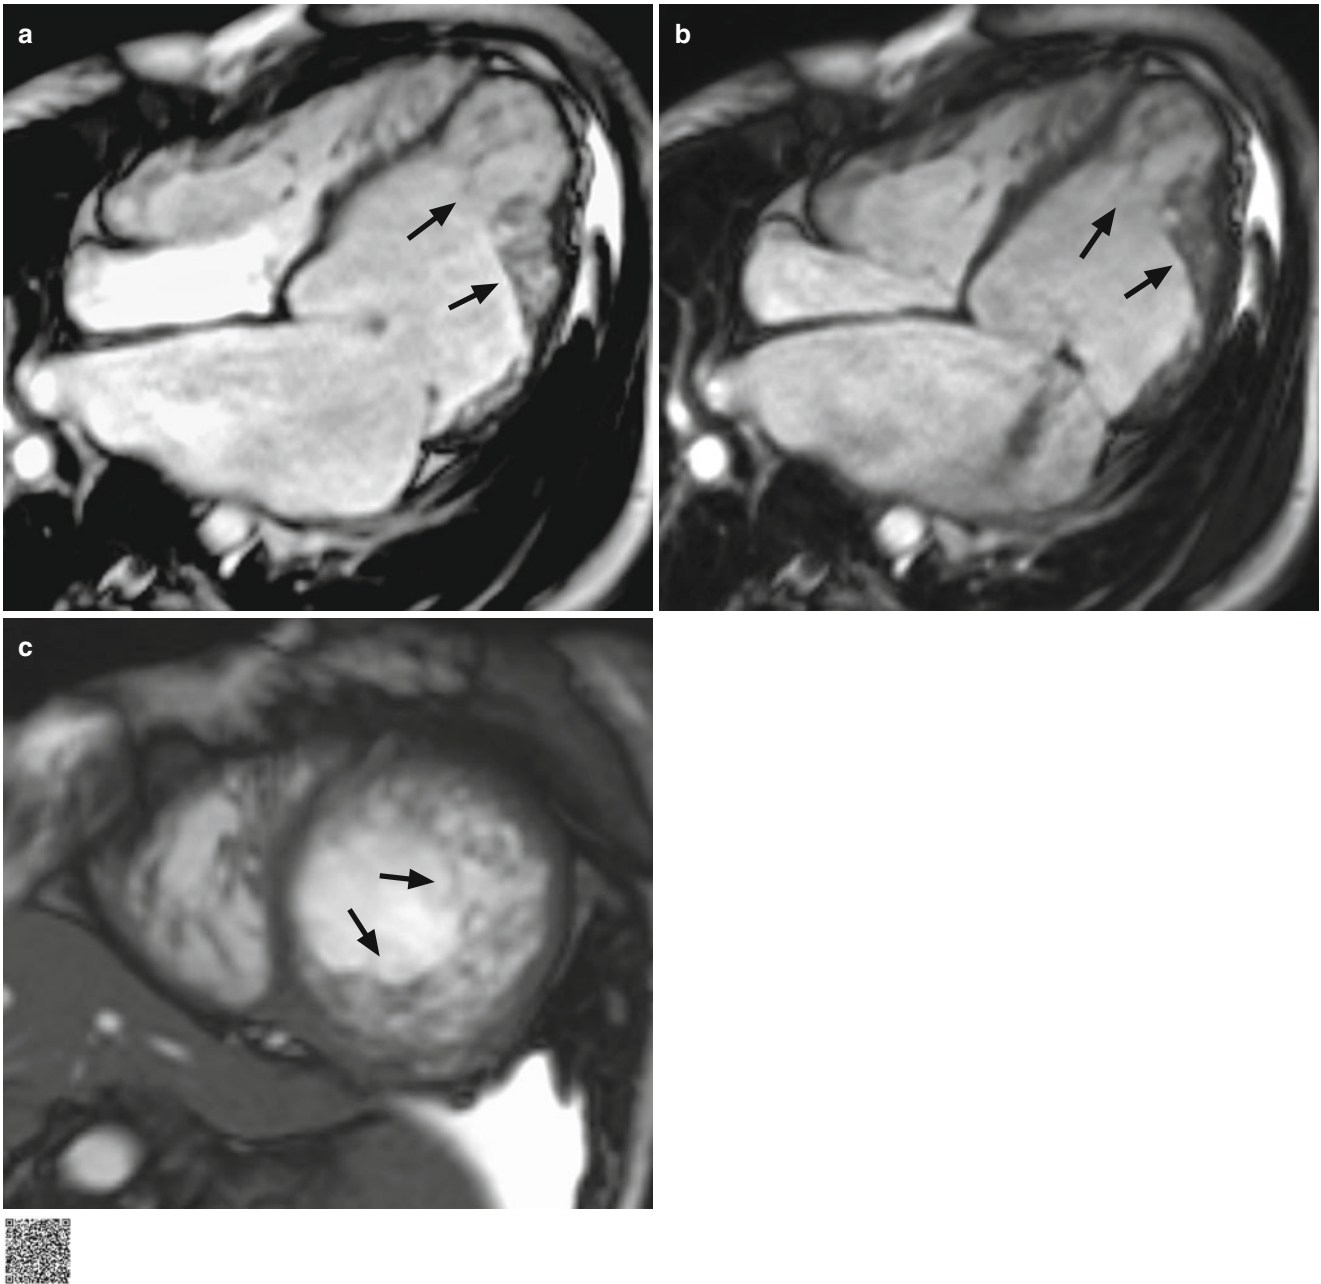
MRI of a patient with left ventricular noncompaction cardiomyopathy (<http://extras.springer.com/2015/978-3-642-36396-2>). (a) Horizontal long-axis cine image at end-diastole. (b) Horizontal
